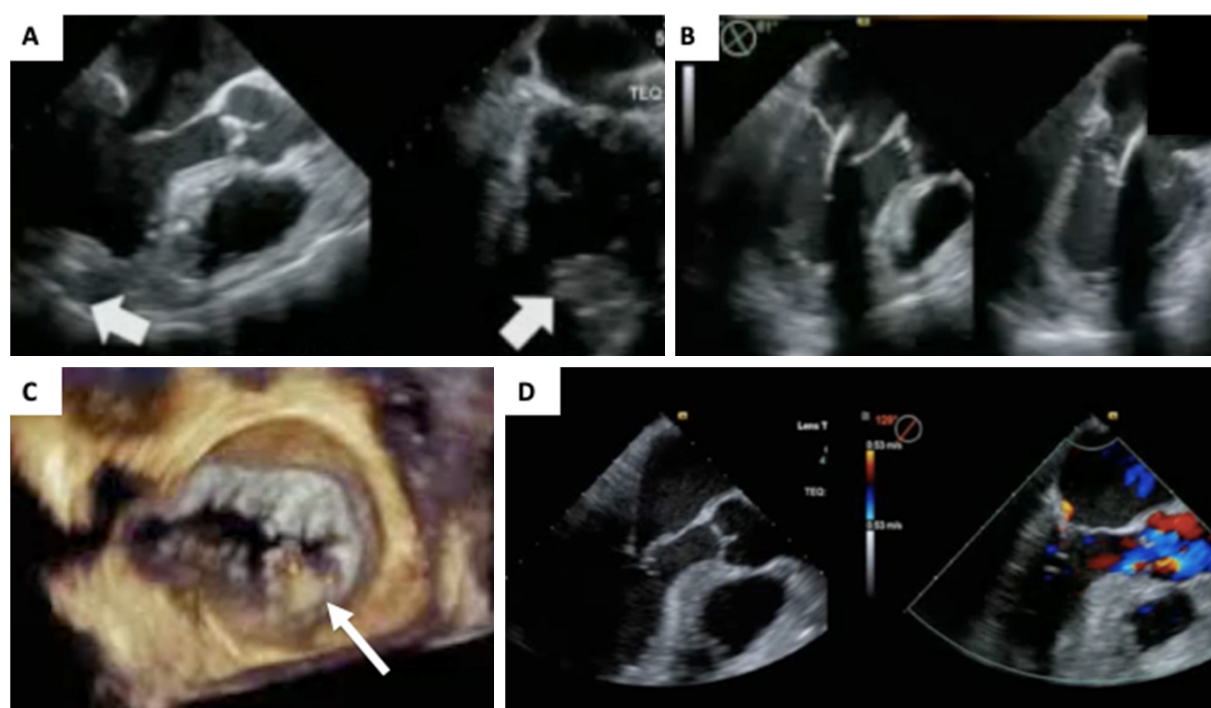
Procedural guidance of the transapical beating heart chordal implantation. A: identification of the LV apex through “finger testing”: the interventionist pushes the apex (white arrow) and the imager checks its position on biplane imaging; B: the system is directed towards the LA on simultaneous biplane LAX and commissural views, avoiding entrapment into subvalvular apparatus. After entering the LA, echocardiographic imaging is switched to 3D surgical view (C), targeting the prolapsing segment (white arrow). After confirmation of leaflet grasping and capture, the device is pulled out from the LV apex and tension is adjusted, until effective MR reduction is shown with color Doppler interrogation (D). LV: left ventricular; LA: left atrium; LAX: long axis; MR: mitral regurgitation
